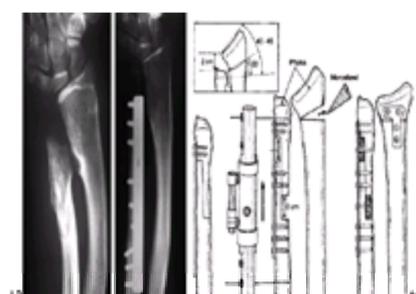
A: Preoperative radiograph of an osteochondromatosis patient with ulnar-shortening and mild radial deformity, with recent progressive loss of forearm
